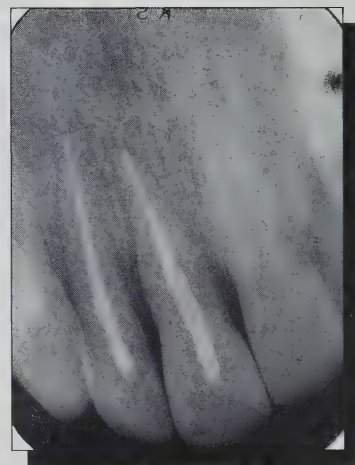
Periapical radiograph of maxillary right central and lateral incisors four days after re-implantation — October 27, 1987.
